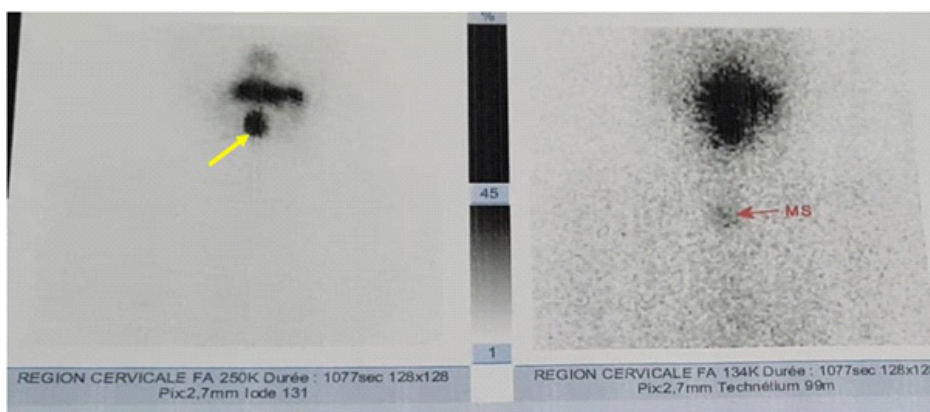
Whole-body scintigraphy with radioiodine-131 performed after IRA therapy which shows a focus of cervical fixation evoking functioning metastases in lymph nodes.
